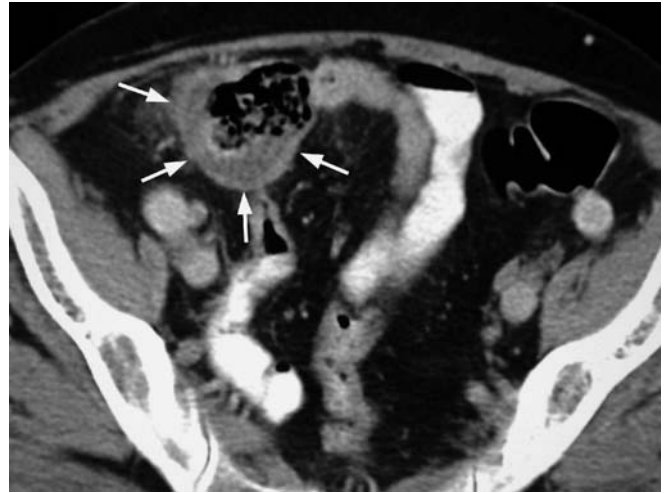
Isolated cecal infarction. CT shows pronounced eccentric cecal wall thickening (*arrows*) that may easily be misinterpreted as a neoplastic pathology if ignoring the clinical constellation
